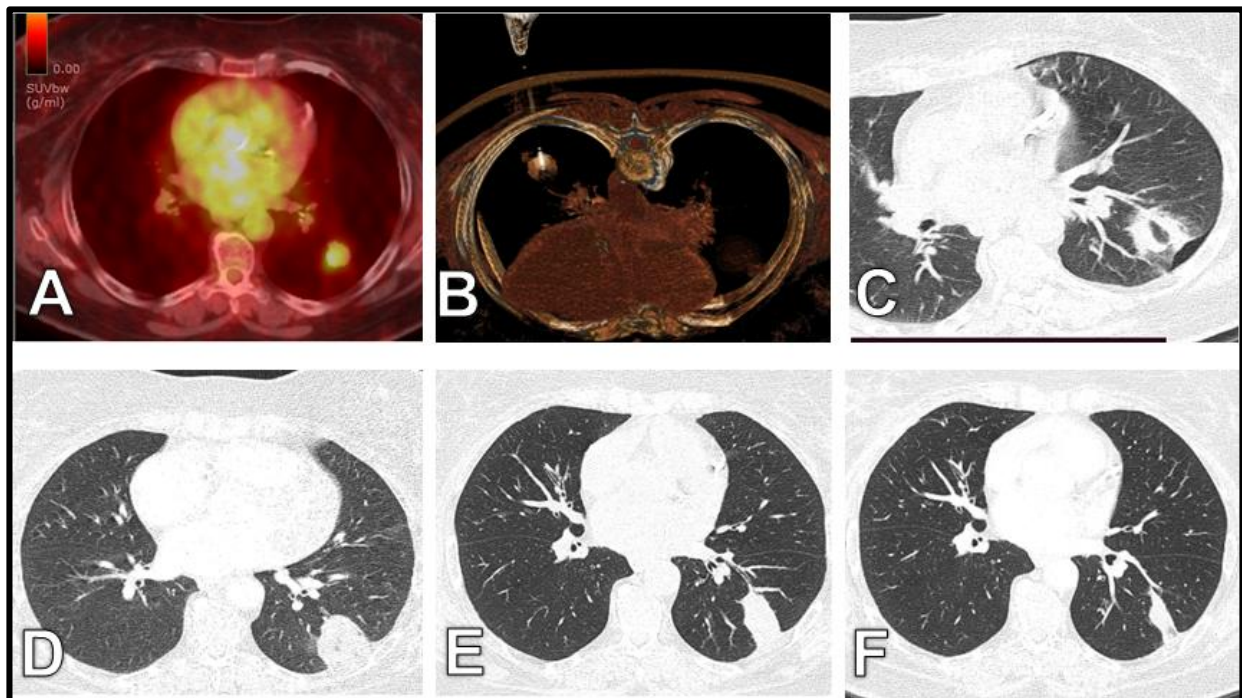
A 62-years-old female had a nodule at the left lower lung lobe, 6 months after colon cancer resection. [A] PET-CT revealed newly developed left lower lobe lung nodule [16 mm in diameter with SUVmax 5.2]. [B] 3D image at prone position revealed MWA antenna at the center of the nodule. [C] Immediately post-ablation, evidence of GGO all around the nodule with mild amount of pneumothorax. [D] 1 month after ablation, evidence of enlarged size with small central cavitation. [E] 3 months after ablation, loss of cavitation with decreasing size. [F] 6 months' post-ablation, the lesion shrank to fibrous cord.
